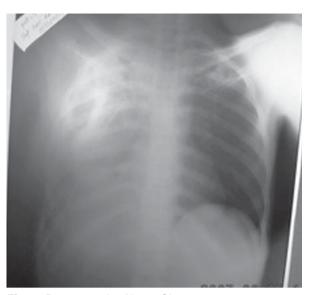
Post operative X-ray, Chest:
